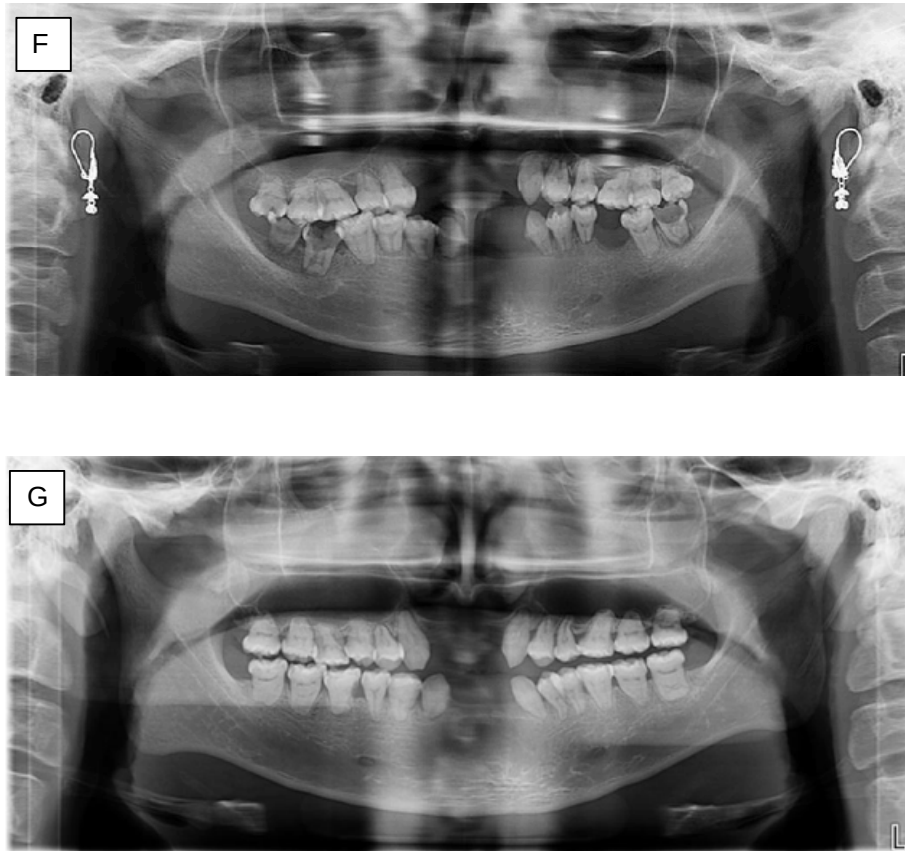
Radiographic examination (A, B, C) Bulbous crown appearance and multiple pulp stones in the pulp chamber, (D) obliterated pulp chamber, (E) crescent-shaped remnants in the pulp chamber (F, G) OPG of Patient A and Patient B.
